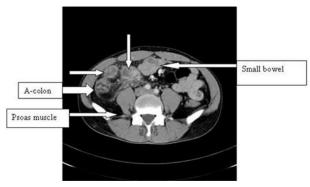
Pre-operative computed tomography scan of the abdomen. The largest abscess is located at the ascending colon mesentery, anterior to the right psoas muscle (vertical arrow). There are several smaller abscesses over the omentum, and paracolic gutter (horizontal arrow).
